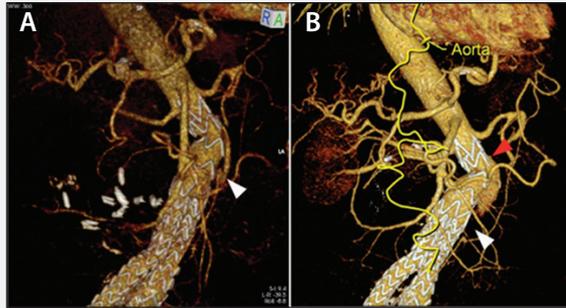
One-year follow-up CTA showing a type II EL from IMA (white arrowhead, A) and its evolution in type Ia EL after 6 months with proximal extension to the free-flow proximal edge of the prosthesis (red arrowhead) and change of the flow dynamics inside the sac with occlusion of the previous feeding IMA (white arrowhead, B).
